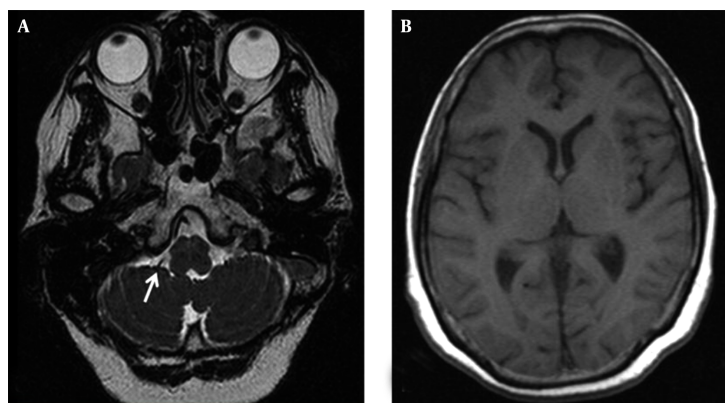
Head MRI showing the right trigeminal nerve compressed by the right posterior cerebellar artery (A), not by abnormal growth of the cerebral tissues (B).
